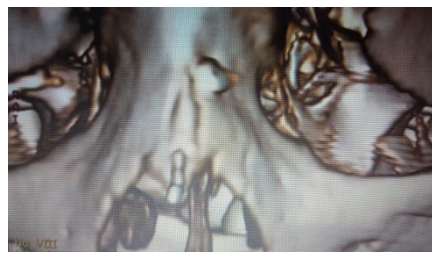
CT scan of a median congenital fistula with fistulogram showing its path
